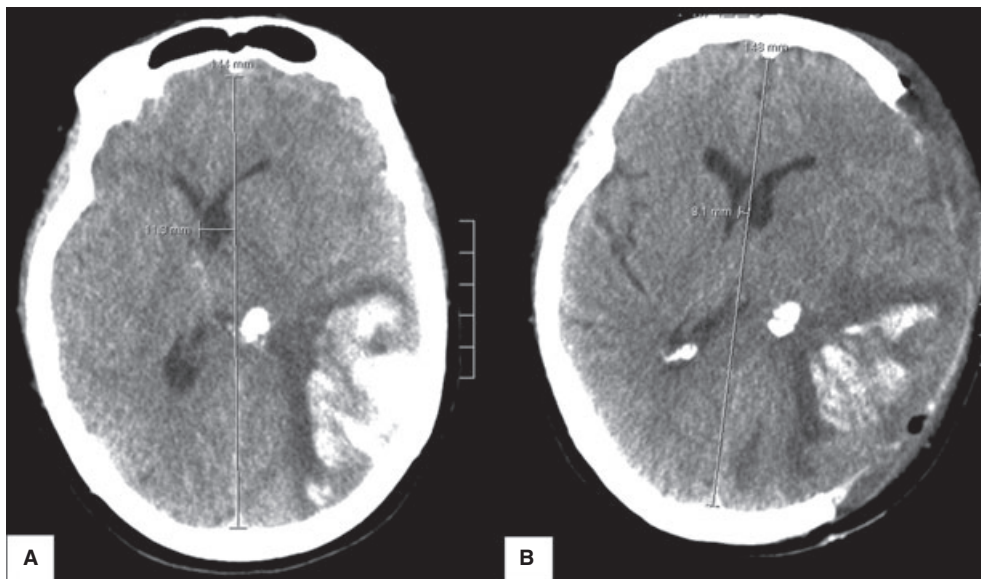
(A) Computed tomography (CT)-scan of the brain of a patient with cerebral venous and sinus thrombosis (CVT) who became comatose because of transtentorial herniation by a large left-sided parieto-temporal hemorrhagic infarct. There is mass effect and shift of midline structures to the right (midline shift 11 mm). (B) CT scan several hours after hemispherectomy. The midline shift is reduced to 3 mm. After the procedure the patient recovered with mild neurologic sequelae.
